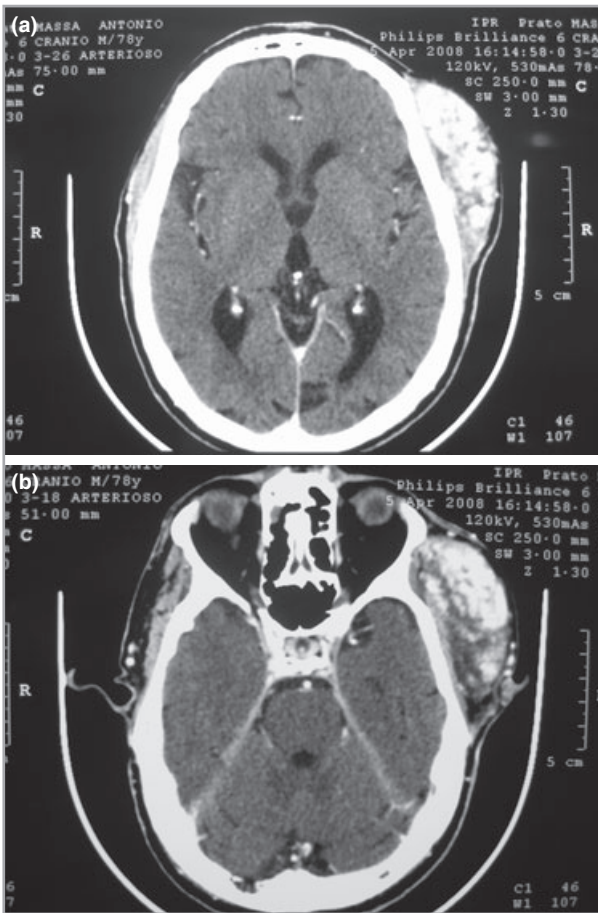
(a, b) Computed tomographic scans showing a 7 × 3 cm mass above the squamous temporal bone with nonhomogeneous enhancement after contrast medium injection. The lesion extended inferiorly to the infratemporal fossa and superiorly to the parietal bone. Although the osseous outer table was uninjured, flattening of the ipsilateral curvature can be seen. The overlying skin was undamaged.
